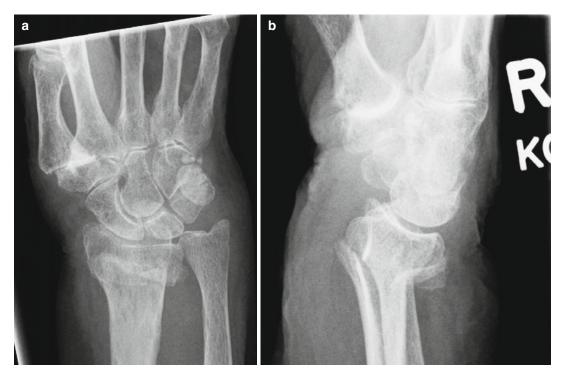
AP (a) and lateral (b) radiographs of a dorsally displaced distal radius fracture in a 92-year-old woman
